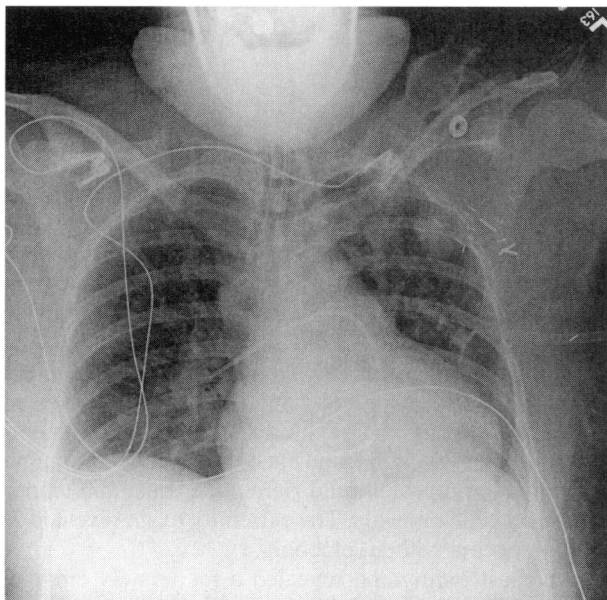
The chest radiograph shows a moderately enlarged cardiac silhouette with patchy right lower lobe consolidation.
